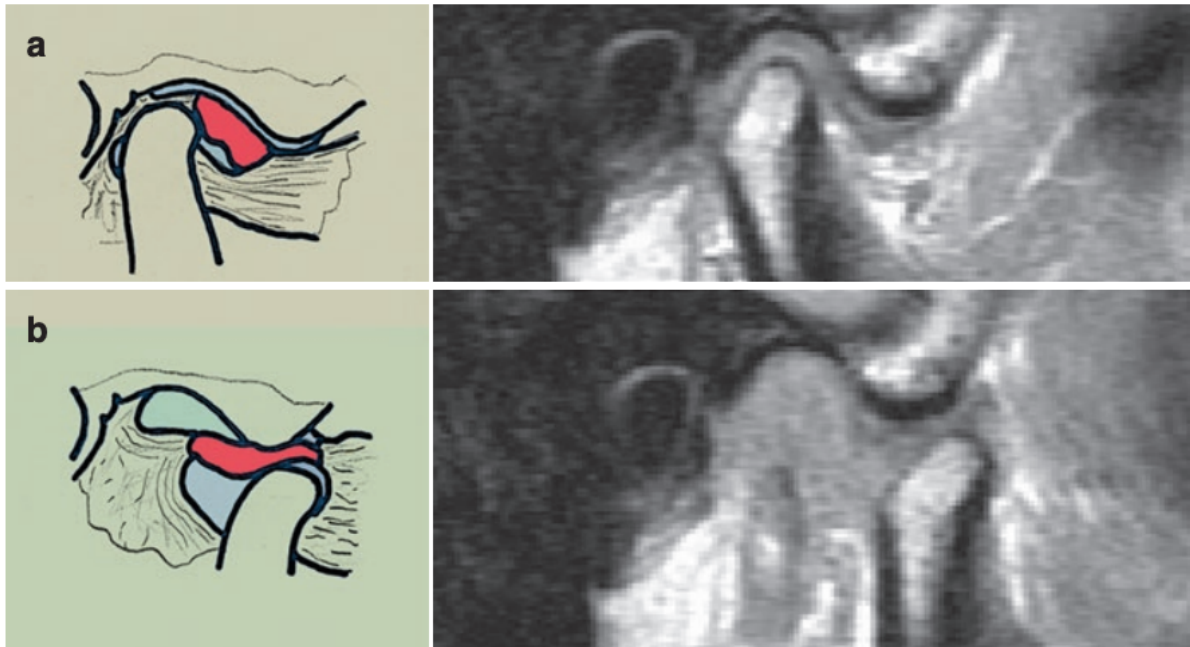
MRI of ADDwR. MRI of ADDwR: a) closed and b) open mouth positions (Bhargava, 2021)
